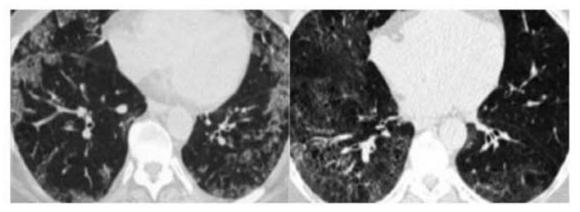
CTD-ILD showing NSIP pattern on HRCT. Both pictures are from biopsy proven connective tissue disease and show obvious ground glass opacities with superimposed fine reticular densities as a result of thickening of the intralobular septa. Notice the lack of honeycombing excluding UIP as diagnosis.
